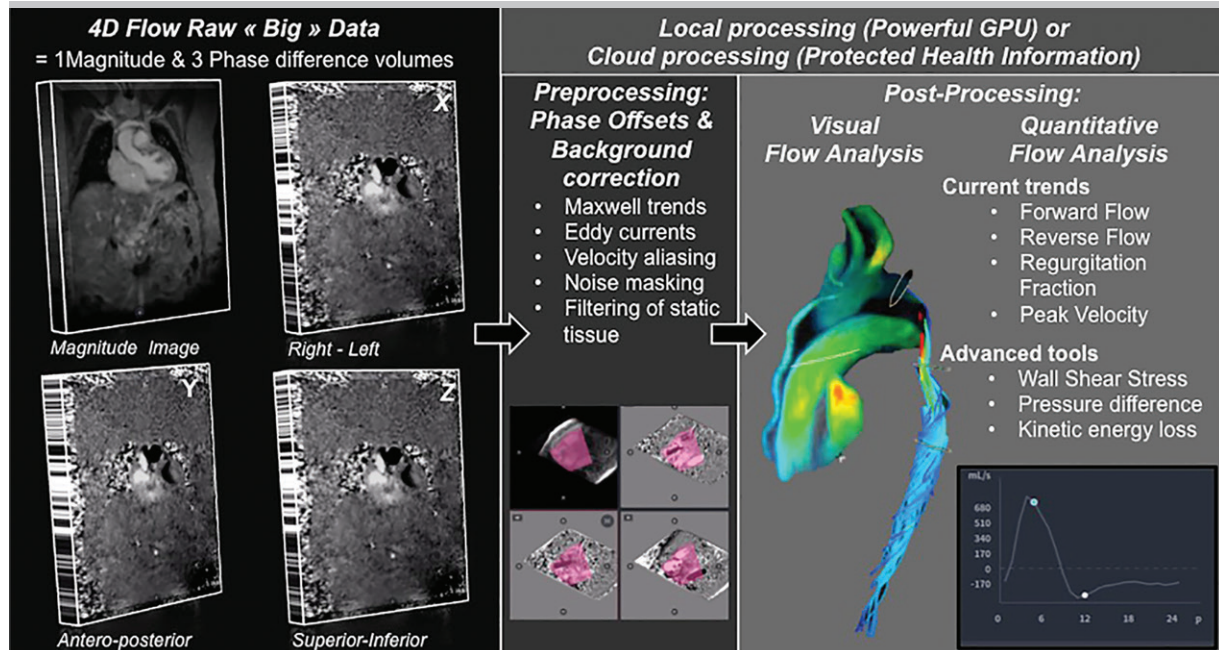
Four-dimensional flow MRI provides sets of 3D volumes over time (4D). Each 4D volume contains one magnitude volume and three phase-difference volumes encoded in the three directions of space (x, y, z). Raw data are preprocessed then postprocessed using local or online software. After preprocessing for phase-offset correction, retrospective postprocessing starts with visual analysis followed by quantitative analysis of the datasets. GPU = graphics processing unit.
